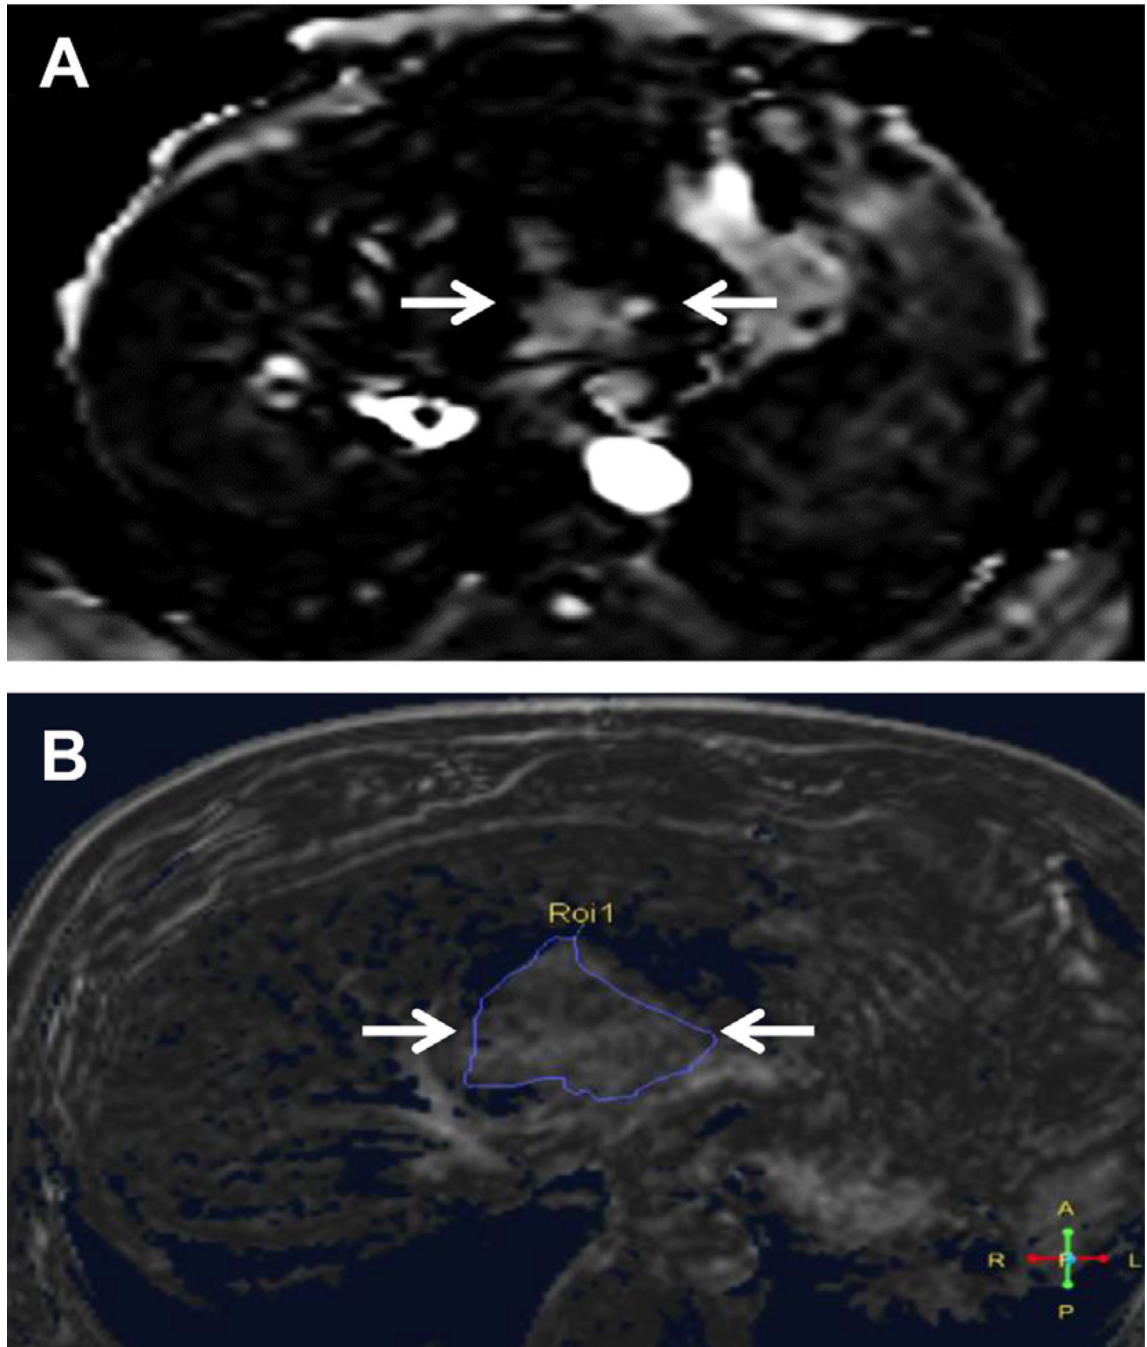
HCC (*arrows*) shows flow in the subtraction image of FAIR-ASL sequence (*A*) in a similar manner to the enhancement showed during the arterial phase (subtraction image) of a DCE-MR imaging sequence (*B*).
